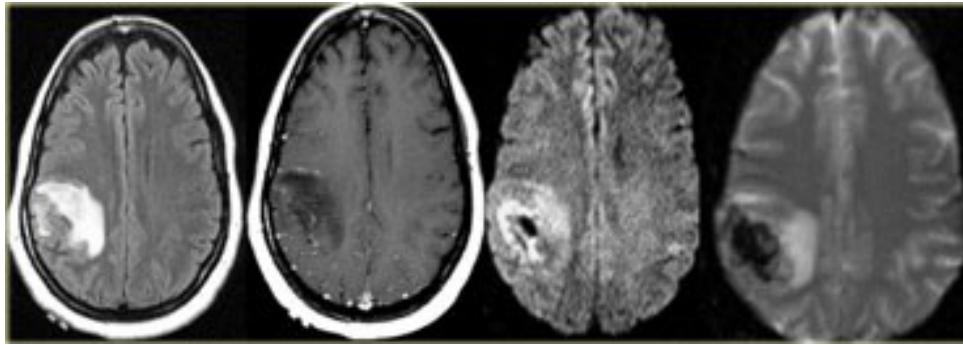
CT of a hemorrhagic stroke (Ashok Srinivasan et alRadioGraphics, 2006)
